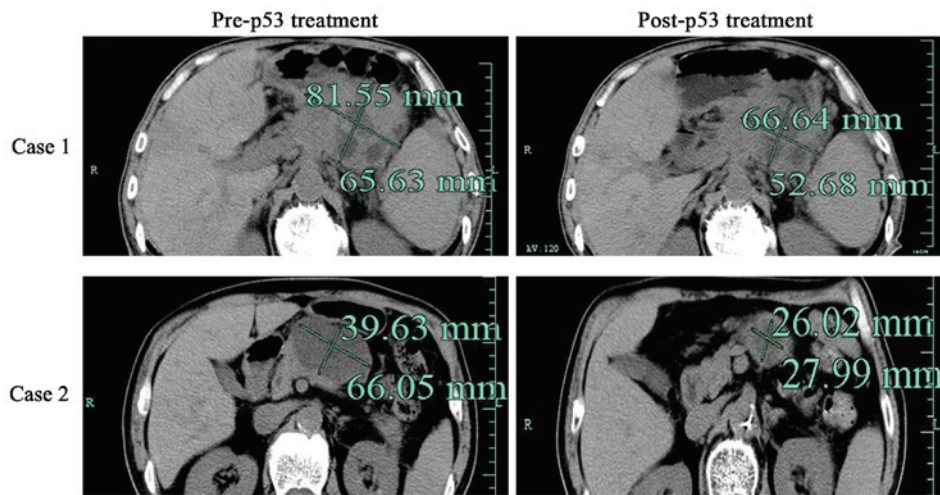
Computed tomography was used to assess the effect of adenovirus-mediated p53. Representative images of computed tomography in patients with pancreatic cancer prior to or following rAd-p53 treatment, as indicated. rAd-p53, recombinant human adenovirus-p53.
